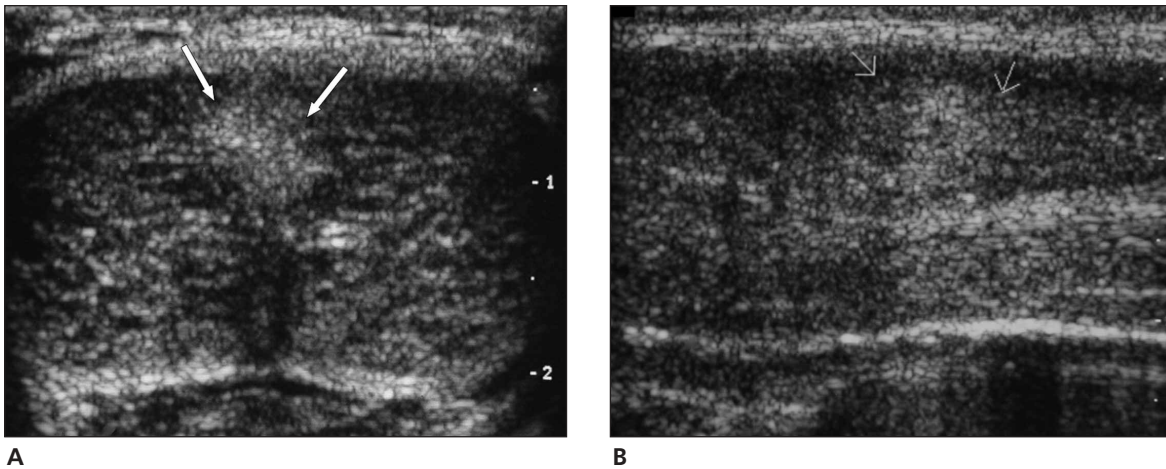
Less common variant of PD showing a palpable echogenic nodule on the dorsal aspect of the septum (arrows). A, Axial sonogram, dorsal access. B, Longitudinal sonogram, dorsal access.
